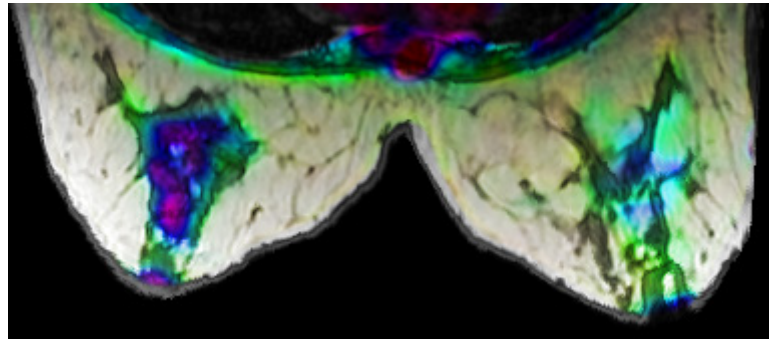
Image created using the HSL (hue, saturation, lightness) color space. Hue=PET, Saturation=CT, Lightness=MRI.
